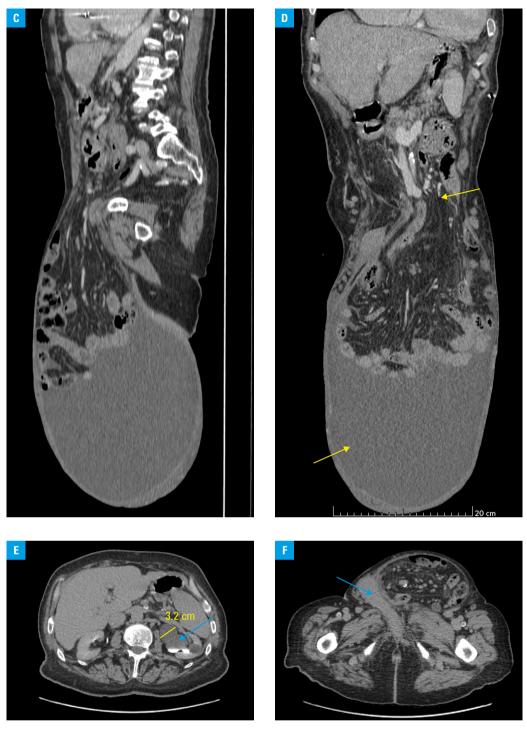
C, D – sagittal computed tomography (CT) image showing massive inguinal hernia, hernial opening (upper arrow) with a huge amount of free liquid (lower arrow); E – axial CT urogram showing severe left hydronephrosis (arrow) with considerable dilatation of the proximal ureter (scale bar); F – axial CT image depicting the penis (arrow) inside the hernial sac
